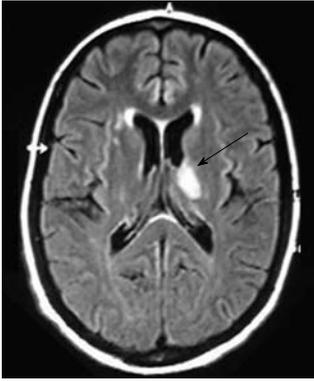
Magnetic resonance imaging of the head showing a 1.5-cm, high-signal lesion in the left thalamus, suggestive of ischemic injury (arrow).
